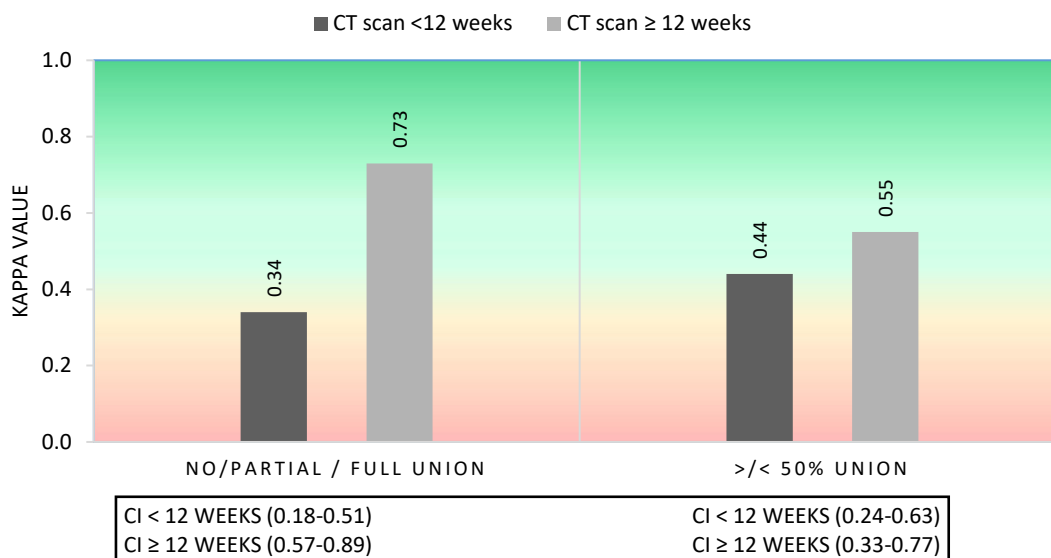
Interrater agreement for each category, separated for patients with CT scans <12 weeks (n = 33) and ≥12 weeks (n = 27) after operative intervention.
